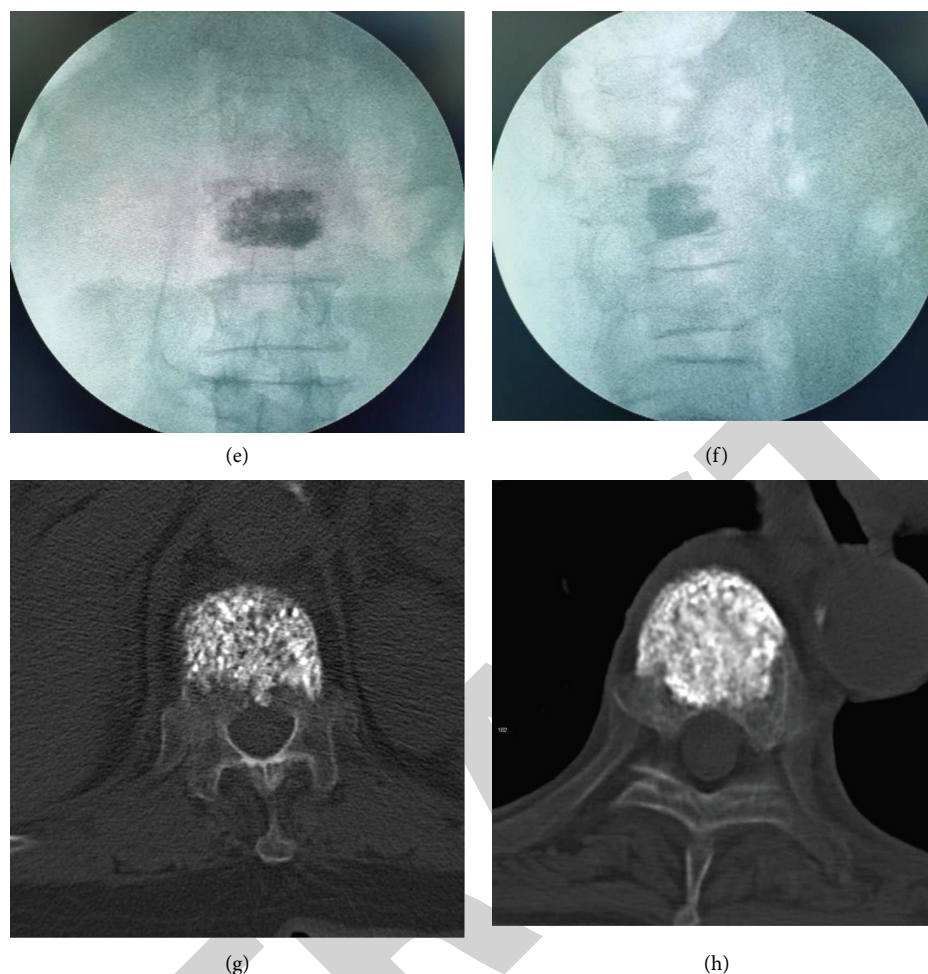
Intraoperative and postoperative CT images of unilateral arcuate vertebroplasty. (a, b) show the front and side views after successful puncture of the arcuate puncture cannula; (c, d) show the front and side views of the arcuate guide needle placed in the vertebral body; (e, f) show the front and side views after bone cement injection; (g, h) show the CT images after bone cement injection.
